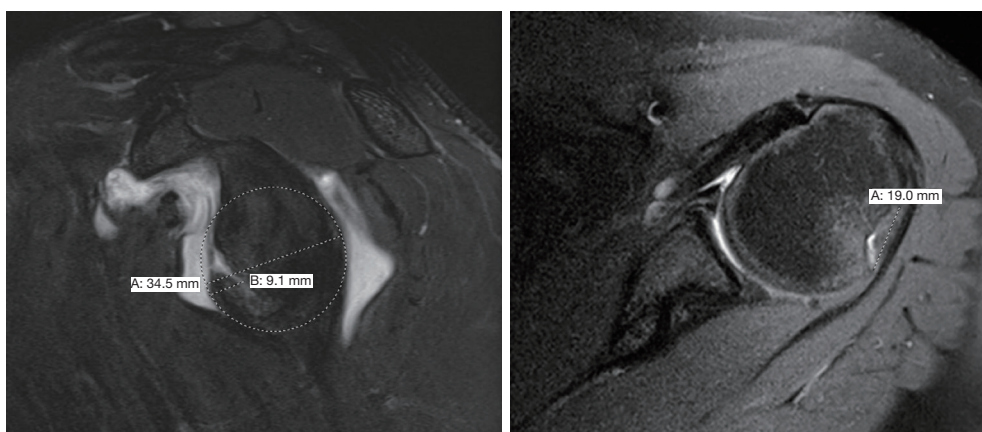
Bipolar bone loss. MRI sagittal cut on left showing glenoid bone loss with glenoid track calculated as $0.83 \times (34.5 \text{ mm}) - 9.1 \text{ mm} = 19.5 \text{ mm}$; axial cut on right showing Hill-Sachs interval measured at 19.0 mm. MRI, magnetic resonance imaging.
